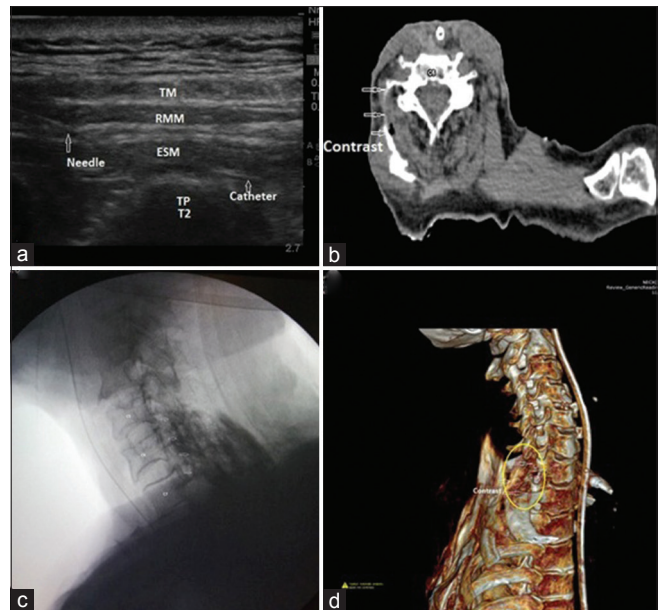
(a) Ultrasound image showing catheter insertion during erector spinae plane block, (b) x-ray image of contrast spread, (c) CT image of contrast spread (transverse section at C6 level), (d) reconstructed 3D CT image showing contrast spread to wards antero-lateral side of C6 and C7 vertebra
